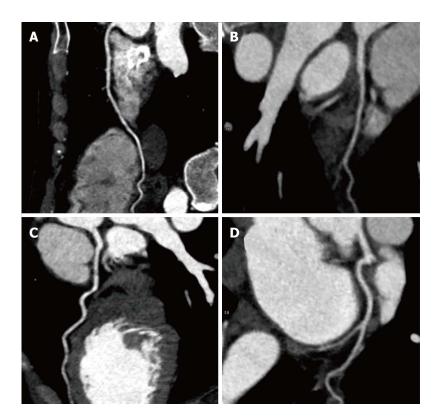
Forty-six-year-old woman, carrier of sickle-cell trait and alpha-thalassemia trait, presenting with silent myocardial infarction. Findings and technique Computed tomography coronary angiography showing normal coronary arteries with no plaque and a global calcium coronary score = 0. A: Right coronary artery; B: Diagonal branch; C: Left coronary artery; D: LIV: Left interventricular coronary artery.
